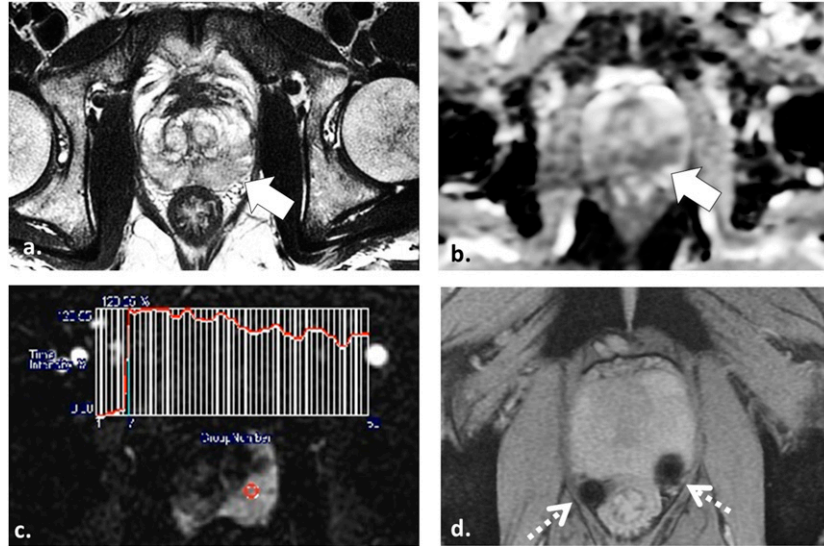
55 year old undergoing radiotherapy planning multiparametric (MP)-MRI for stereotactic body radiotherapy. Axial T_2 weighted (T_2 W) fast spin echo (a), axial apparent diffusion coefficient map (b) and axial image obtained from dynamic contrast-enhanced sequence (c) demonstrate a low T_2 W signal intensity lesion in the left mid-peripheral zone (white arrow in a) with mild restricted diffusion (white arrow in b) and a Type III washout curve (c) consistent with patient's known tumour in this location. Axial multiecho gradient recalled echo image (d) depicts two platinum fiducial markers (dotted arrows) which enable the treatment planning MP-MRI to be fused onto treatment planning CT images (not shown).
